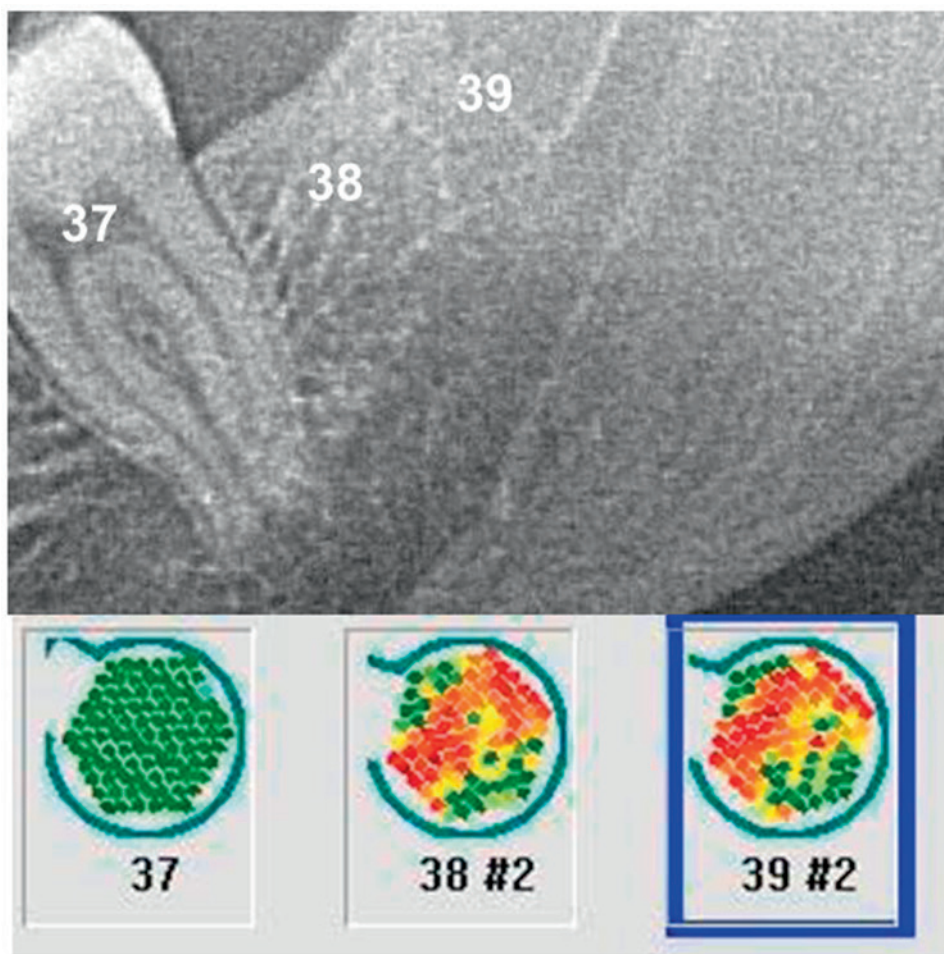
Comparison of panoramic radiograph (OPG) and TAU measurement which shows specific via green dense, inconspicuous structures) and red (low-density, conspicuous structures) resolution.
